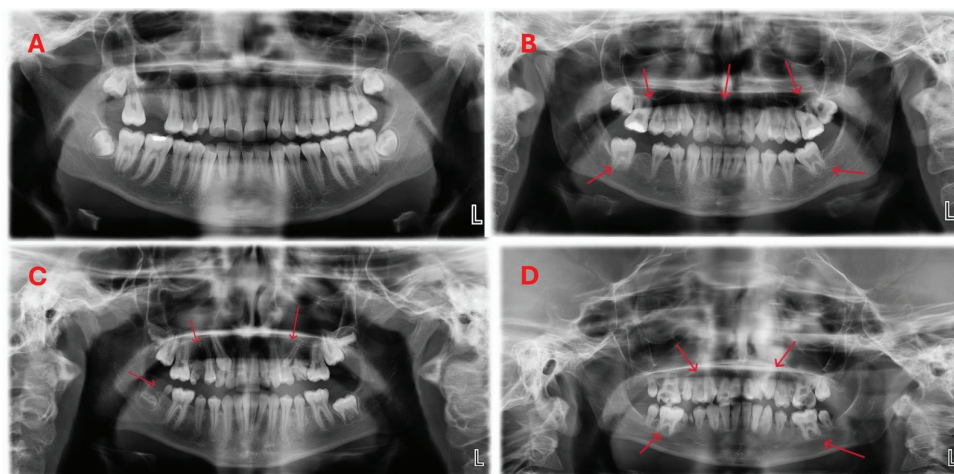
Panoramic radiographs of a normal child and the childhood cancer survivors. A) A 13-year-old girl with normal root lengths and tooth morphology. B) A 13-year-old girl with short, V-shaped deformed roots. C) A 12-year-old girl with undeveloped or hypoplastic teeth. D) A 12-year-old boy with short and malformed roots in all teeth
